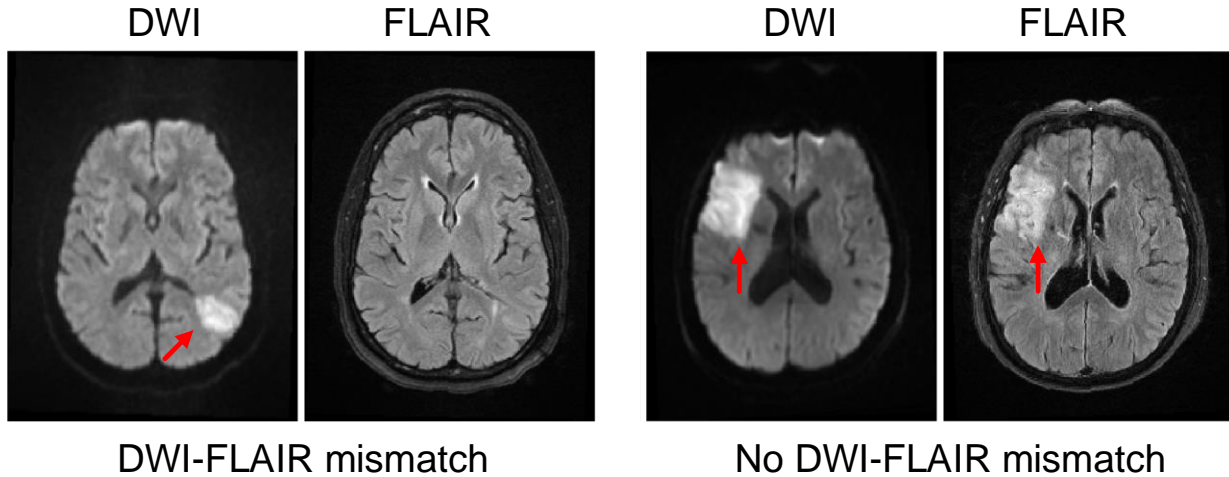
An example of DWI-FLAIR mismatch and no DWI-FLAIR mismatch. LEFT: presence of DWI-FLAIR mismatch (TSS = 1hr); RIGHT: absence of DWI-FLAIR mismatch (TSS = 8hrs). Hyperintensities are indicated by the red arrows.
